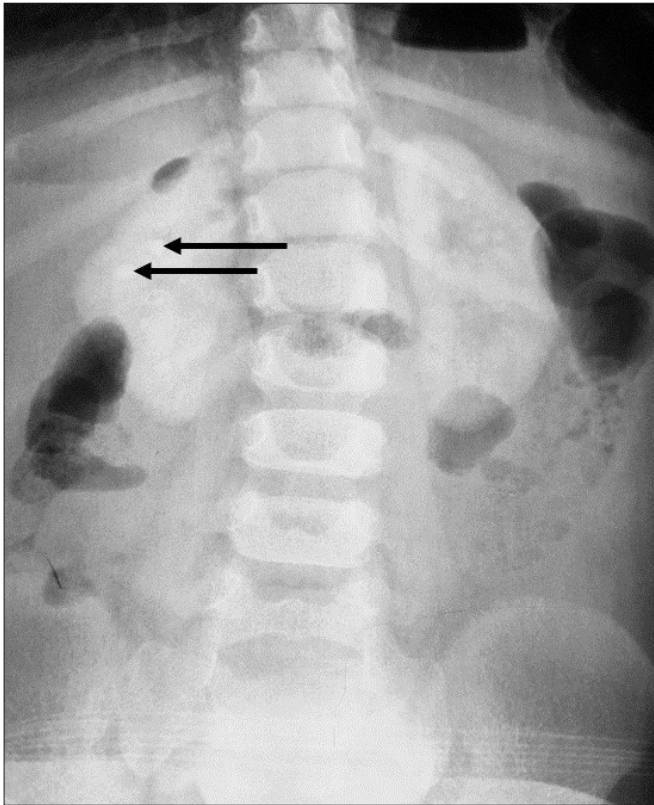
Abdominal x-ray with primary hyperoxaluria showing nephrocalcinosis, as delineated by the radio-opacities outlining both kidneys, and urolithiasis as indicated by the arrows
